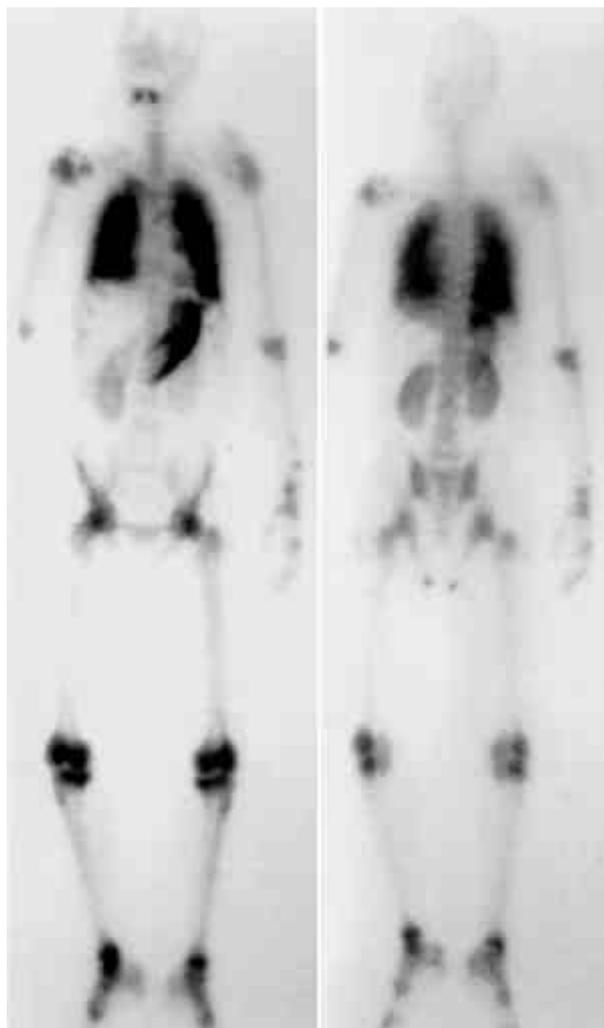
Tc-99m MDP bone scintigraphy of a 32-year-old man with hypercalcemia shows diffusely increased uptake in lung, heart, stomach and both kidneys.
